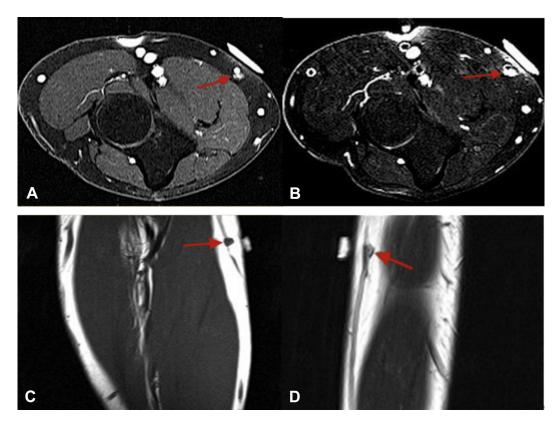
Magnetic resonance imaging of the right forearm demonstrates a small T1 hypointense, T2 hyperintense superficial soft tissue mass (arrows) noted within the volar and medial aspect of the forearm. A T1-weighted axial image. B T2-weighted axial image. C T1-weighted postcontrast coronal. D T2-weighted postcontrast coronal image.
